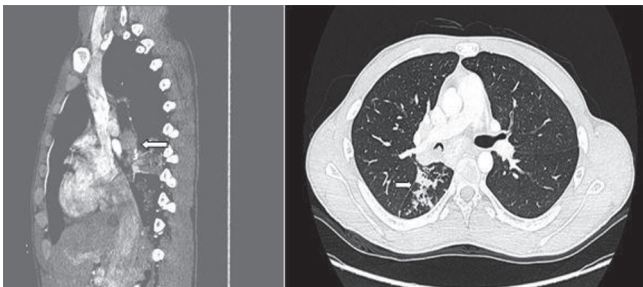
Contrast enhanced computed tomography of chest-mediastinal window sagittal view shows an enhancing endobronchial mass lesion seen occupying the right lower lobe main bronchus causing occlusion(left arrow) and axial image- lung window shows nodular opacities in the medial basal segment of right lower lobe(right arrow).
